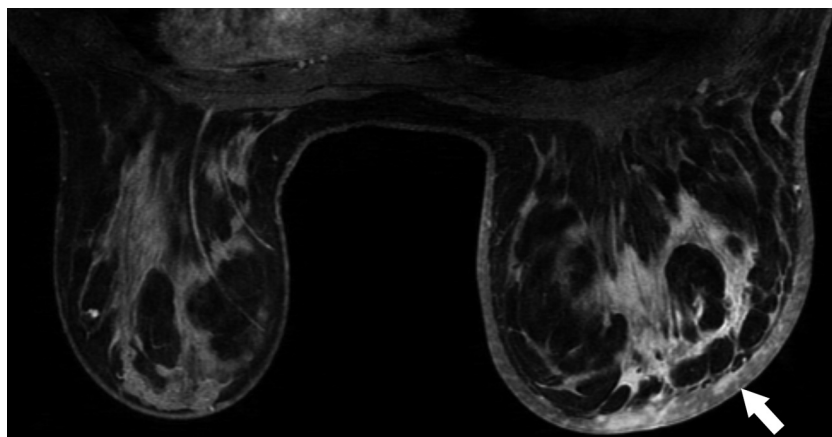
A 42-year-old woman with history of inflammatory right breast cancer, invasive ductal carcinoma, and ductal carcinoma *in situ*. T1-weighted fat-suppressed MR image in the transverse plane obtained after intravenous administration of a gadolinium chelate depicts marked global asymmetric skin thickening due to inflammatory breast cancer (arrow).
